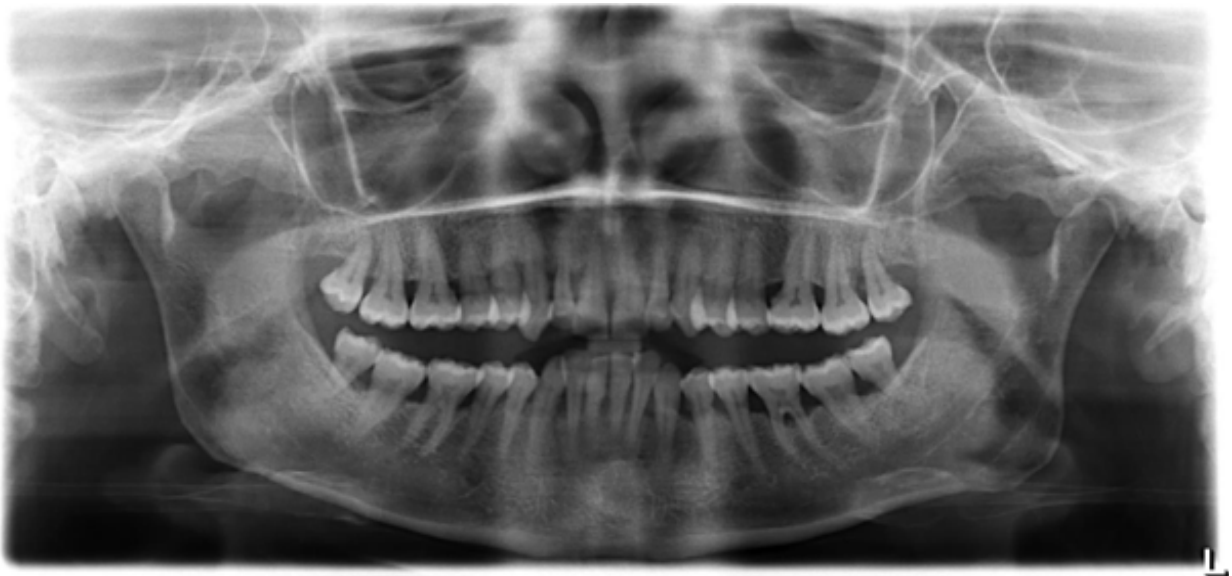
Orthopantomogram 417 x 276 mm (300 x 300 DPI)
